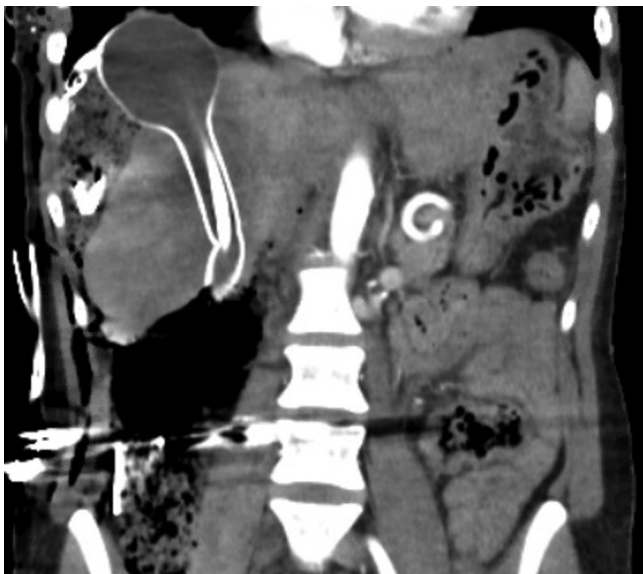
Coronal view CT demonstrating placement of the balloon catheter.
